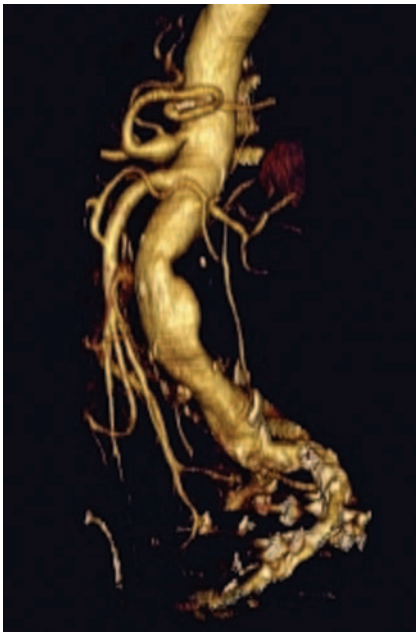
CT angiogram reconstructed on the Vitrea workstation shows the abdominal aortic aneurysm in patient 3.
